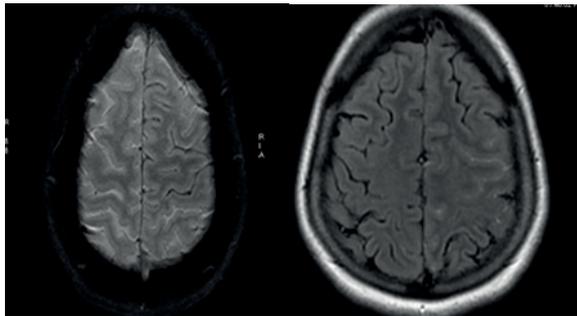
T2 FLAIR & GRE images: Showing linear hyper intensities noted on T2 FLAIR image with GRE blooming in the left parietal region, suggestive of subarachnoid hemorrhage.
